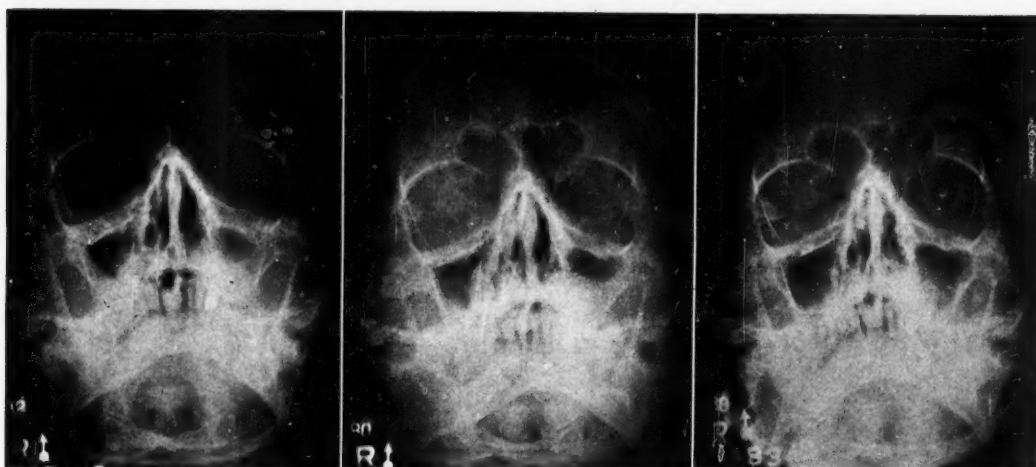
Sinus x-rays before treatment (left), during treatment (center), and after treatment (right) showing increased involvement of left antrum eight days after start of therapy but final complete clearing of right antrum with moderate clearing of left antrum.
